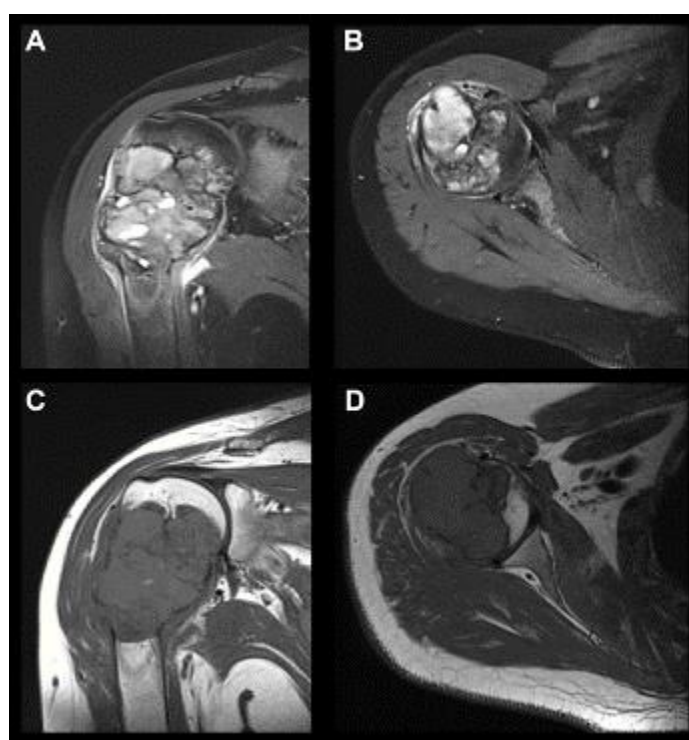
A-D. MRI images of the tumor showing heterogeneous high signal intensity on T2-weighted coronal (Fig. 2-A) and axial (Fig. 2-B) views, and low signal intensity on T1-weighted coronal (Fig. 2-C) and axial (Fig. 2-D) views.
